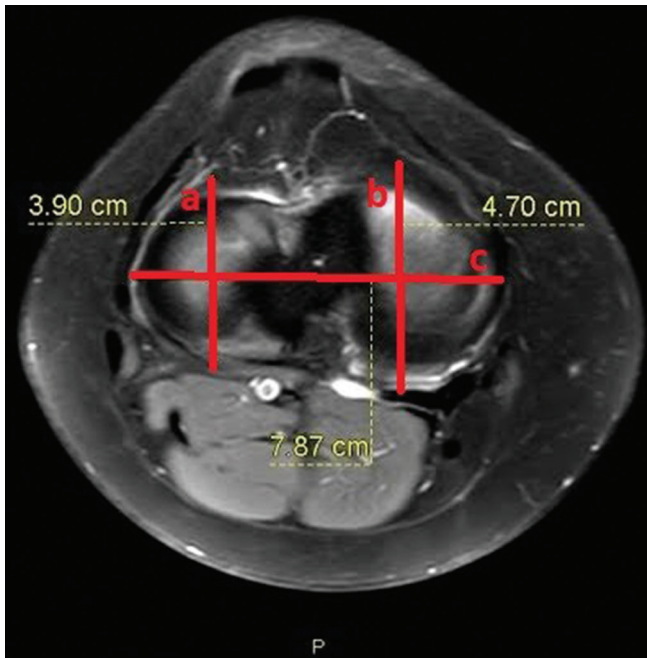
Axial magnetic resonance image of proximal tibia. a: TLAP, b: TMAP, c: TML
